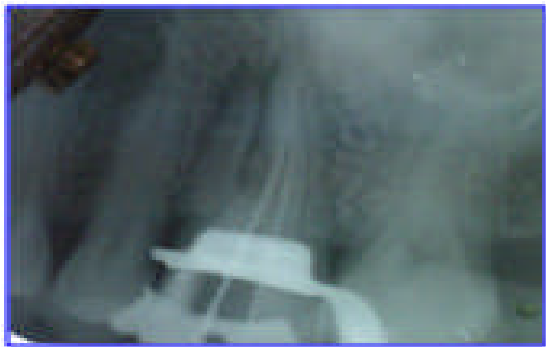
Working length radiograph with instruments in five canals
